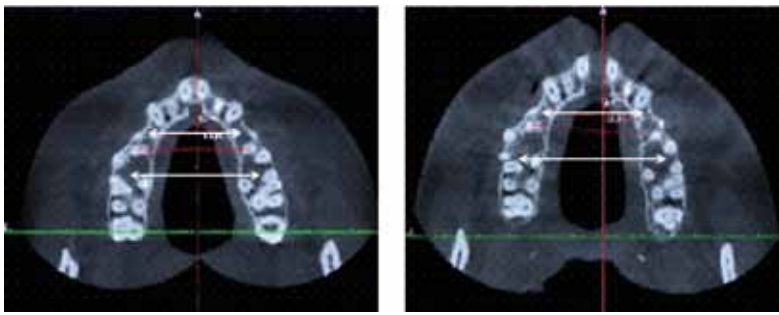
Computed tomogram, patient A., 16 y.o., with upper jaw severe narrowing before (a) and after (b) using a palatal expander with bone fixation.
